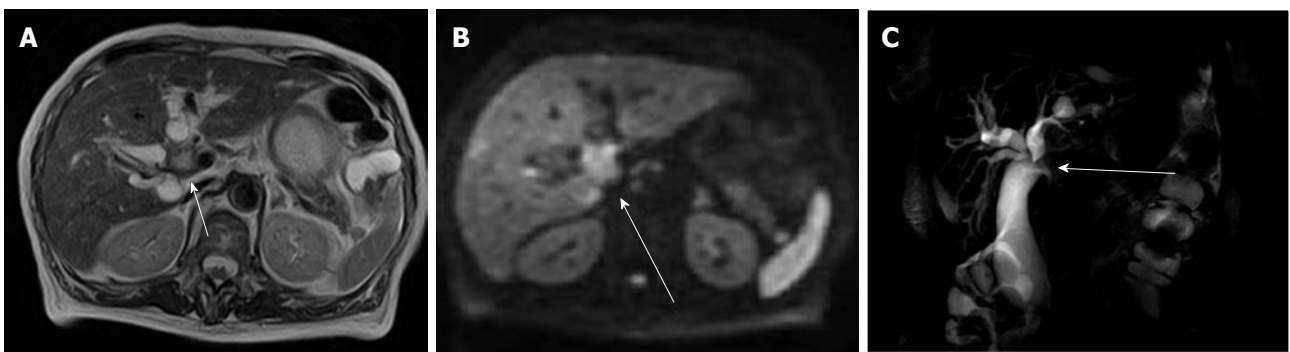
Hilar bile duct cancer in an 84-year-old woman. A: Axial T2-weighted image shows wall thickening and high signal intensity of hilar bile duct (arrow); B: Diffusion-weighted imaging shows high signal intensity in the lesion (arrow); C: Magnetic resonance cholangiopancreatography shows occlusion of the hilar bile duct (arrow).
